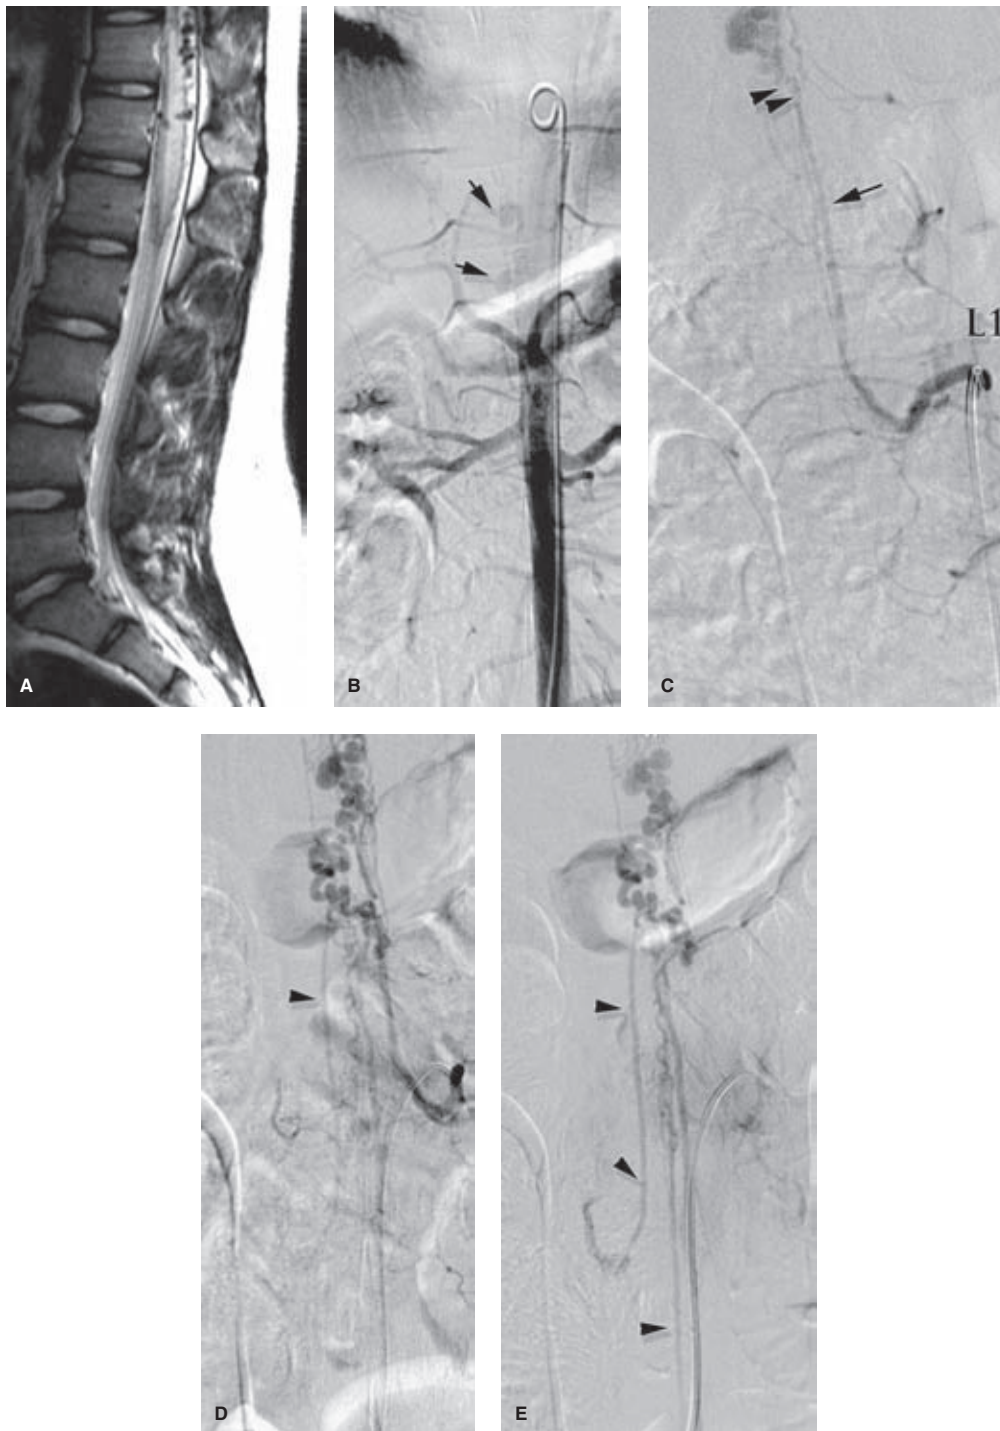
(A–E) Spinal angiography requires, amongst other things, knowing the difference between an artery and a vein. A middle-aged patient presented with acutely progressive decline of spinal function. The sagittal T2 MRI (A) demonstrates a markedly hyperintense and expansile appearance of the cord with prominently distended flow-voids on the pial surface of the conus. A pigtail aortogram (B) of the descending aorta faintly demonstrates some of the vessels (arrows in B) seen on the MRI, but does not help enormously otherwise. The left L1 injection (C) demonstrates an enlarged spinal artery (arrow in C) extending up to the cord where distended vascular sacs are filling rapidly at the top of the picture. Sequential images from the left L1 injection (D and E) demonstrate a massively sinuous complex of veins over the conus emanating inferiorly from a venous sac at the top of the picture, with slow centrifugal (normally directed) opacification of the segmental veins (arrowheads in D and E) to the lumbar area draining the congested cord, albeit ineffectively. This lesion is probably best understood as a perimedullary fistula (see Chapter 21). The fistula is likely close to the location of the double arrowheads in (C), with a change in caliber immediately above that level where the receiving venous component of the fistula has become aneurysmally distended. It is vitally important that at the end of a spinal angiogram there should be no confusion as to what represents an artery and what a vein on the images, particularly with reference to planned endovascular or surgical treatment. *Note: The positioning in this set of images would be much improved by centering on the region of the fistula rather than on the catheter tip. Most of the area in the lower half of the picture is wasted.*
